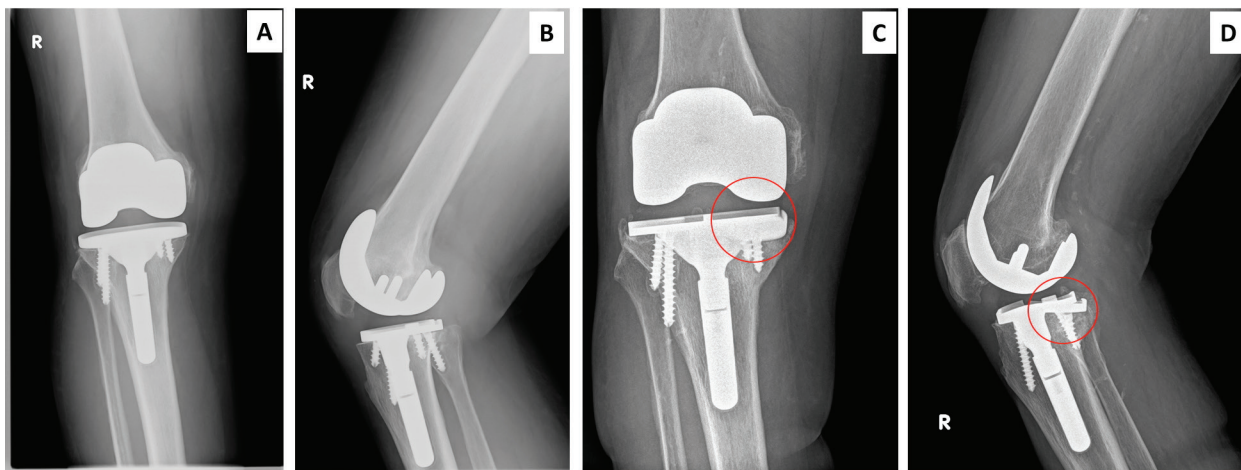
Aseptic loosening and implant failure in a patient with TKA. A, B – postoperative X-ray in 2010; B, C – follow-up X-ray in 2022, evident osteolysis around femoral and tibial component with fracture of the tibial tray (encircled in red).
